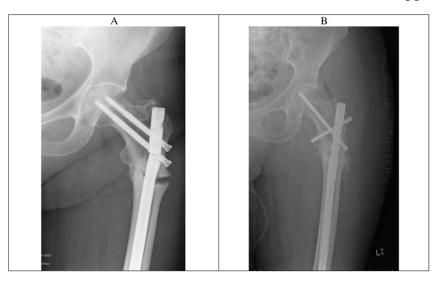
A: Radiograph on admission March 2015 showing broken IM nail and femoral shaft fracture non-union B: follow up radiograph post exchange femoral nailing March 2015.
